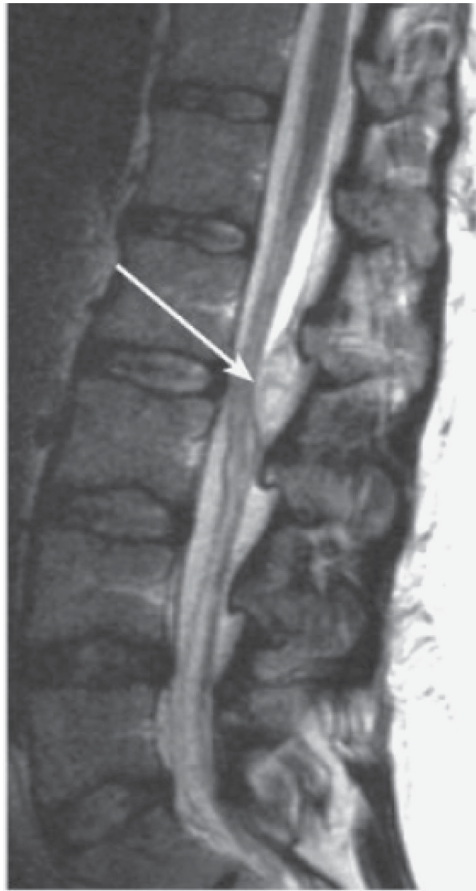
Median sagittal T2-weighted MRI showing intraspinal, ellipsoid fluid collection (arrow) in the dorsal epidural space at disc level L2–3, compressing the dural sac. Epidural abscess complicating epidural analgesia.
